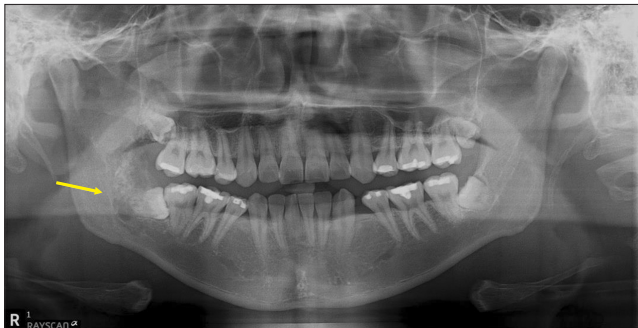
Radiographic image of the right mandible. Panoramic radiograph showing a mixed radiolucent-radiopaque lesion with indistinct margins in the ascending ramus of the mandible (indicated by yellow arrow).
